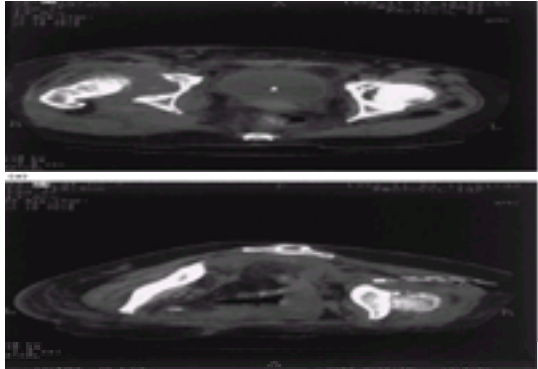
(a) CT scan showing intra-abdominal abscess. (b) CT scan showing intra-abdominal abscess, treated by percutaneous drainage.
